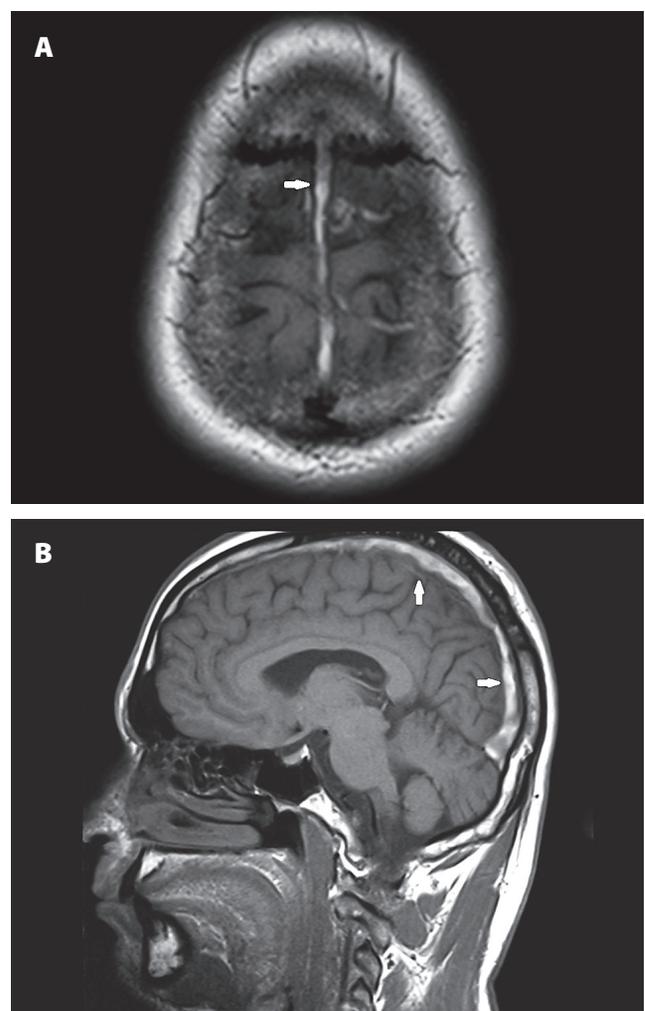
(A). T1-weighted image, axial plane. (B) T1-weighted image, sagittal plane. Hyperintense thrombus in the superior sagittal sinus
